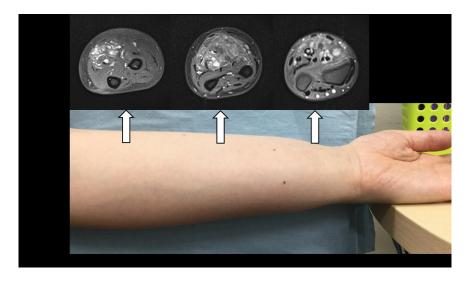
Case 1. The left forearm; proximal, middle and distal portion. MRI imaging in axial cuts showing an extensive T2 hyperintense lesion (venous malformation) occupying the whole flexor compartment.
